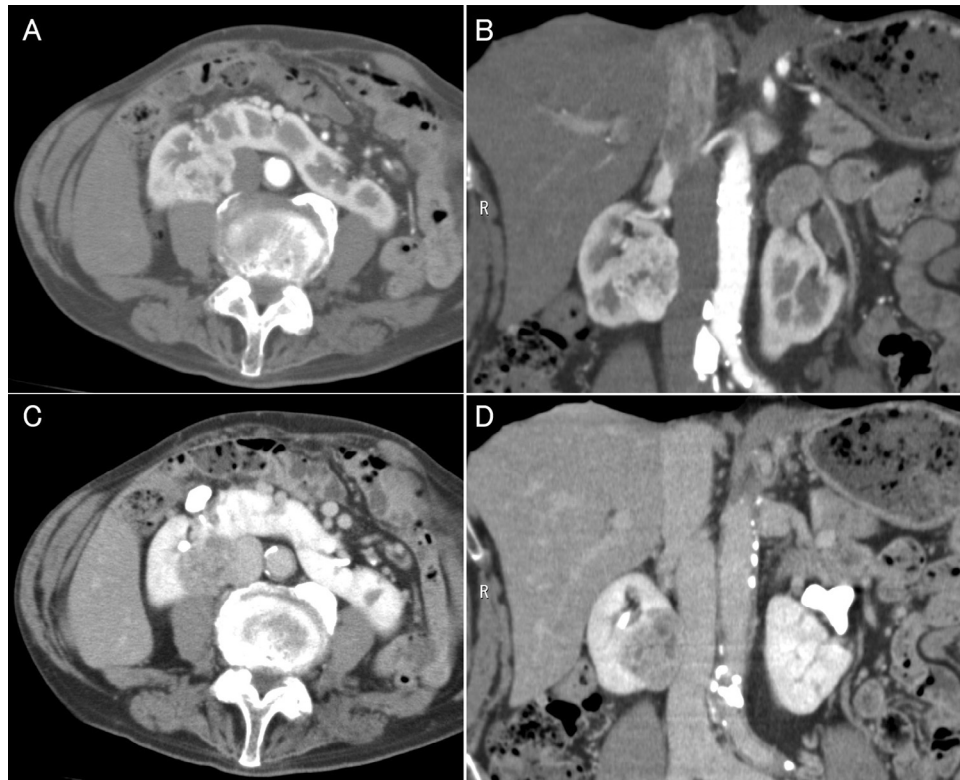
Multiphase contrast-enhanced computed tomography revealed a strongly enhancing tumor of 42 mm diameter in the right side of the isthmus of a horseshoe kidney. (A) Axial image of arterial phase. (B) Coronal image of arterial phase. (C) Axial image of delayed phase. (D) Coronal image of delayed phase.
